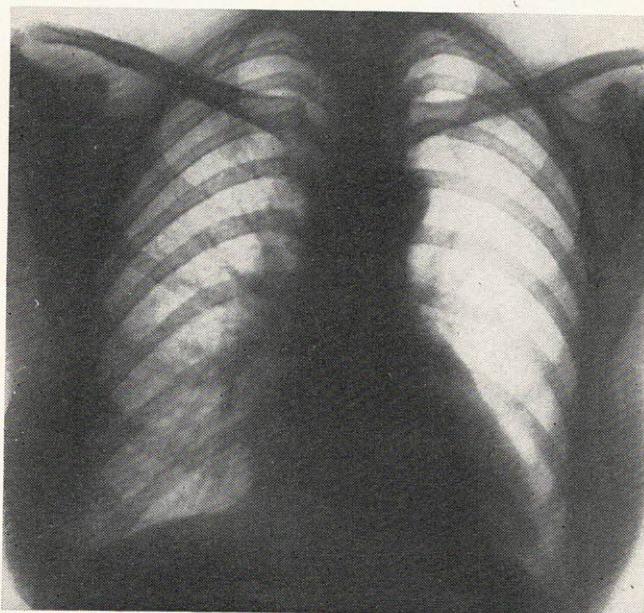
Posteroanterior X-ray of the chest. There is increased radiolucency of the left lung with faint hilar shadow and absence of vascular markings.
